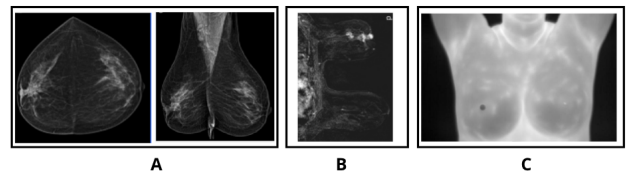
(A) Craniocaudal (CC) and mediolateral oblique (MLO) views of the right and left breasts captured through mammography, (B) magnetic resonance imaging (MRI), and (C) infrared (IR) thermography [7].
